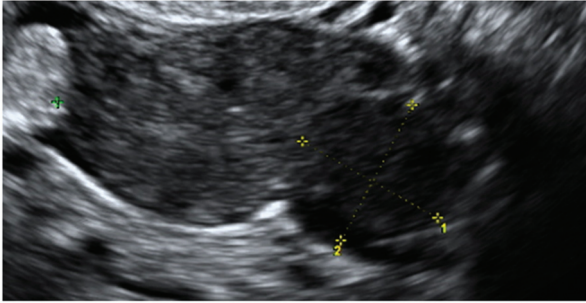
Case II (possible case): Stage IC3. (A) TVUS right ovary, (B) TVUS right ovary with small hyperechoic foci, (C) TVUS left ovary. TVUS, transvaginal ultrasound.
